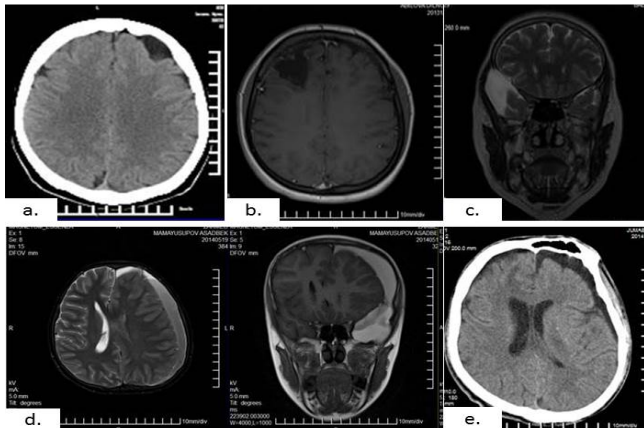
Forms of consequences of TBI (MRI and CT examples)
